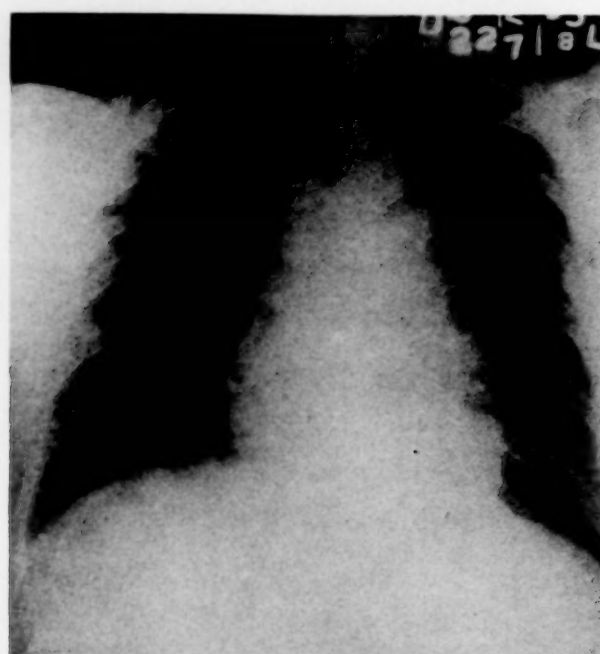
X-ray taken at the completion of radiation therapy, Case iv.
